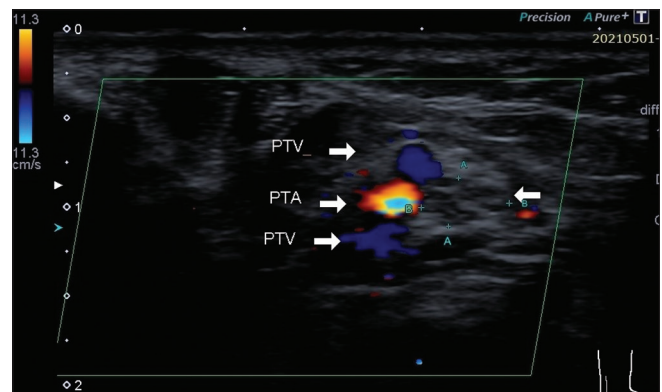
Transverse colour Doppler ultrasonogram of the PTN showing its minor axis (A-A) and major axis (B-B), with the accompanying PTA and paired PTVs. PTN: Posterior tibial nerve, PTA: Posterior tibial artery, PTV: Posterior tibial vein
